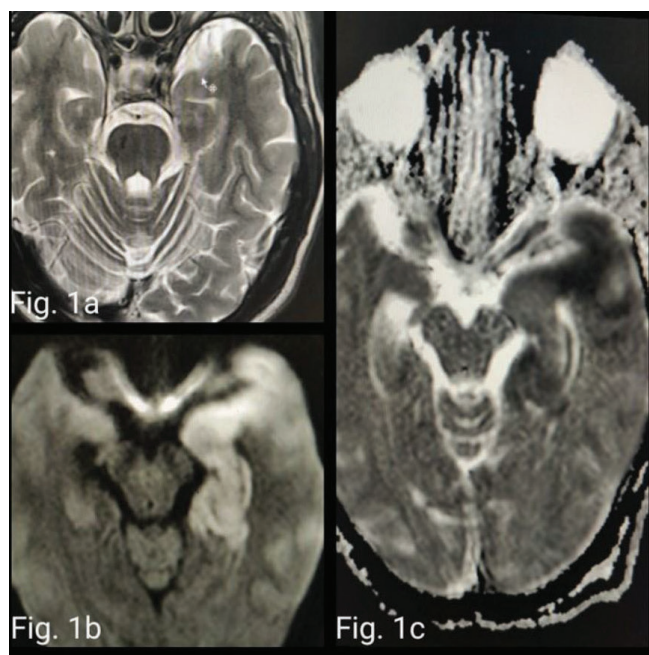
Axial T2W (a) image shows normal signal intensity in bilateral temporal lobes. DWI (b) and corresponding ADC (c) images show diffusion restriction in the left temporal lobe
